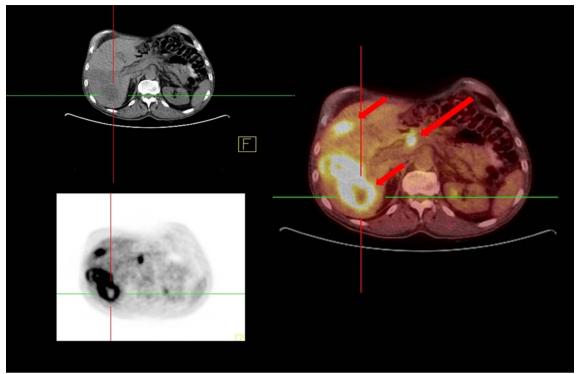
41-year old woman, histollogicaly confirmed as Adenocarcinoma infiltrativum recti, HG2, pT3 N1a. Two FDG avid soft tissue masses located in the liver (S7/8 and S7), SUV_{max} 20.3, consistent with liver metastases (short arrows). FDG avid lymph node in the liver hilum, SUV_{max} 4.55 consistent with metastatic nodal involvement (long arrow).
